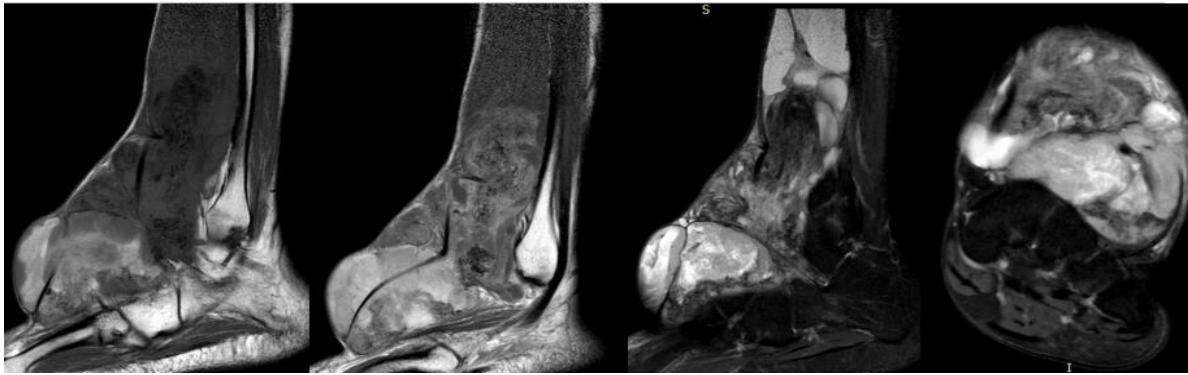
Synovial sarcoma, A 25 year old male patient presented with ankle swelling. MRI Showed well defined lobulated T1 heterogeneously isointense mass with areas of hypointense and hyper intense showing heterogeneous contrast enhancement. The mass has heterogeneous hyper intense T2 signal intensity with hypointense areas.
